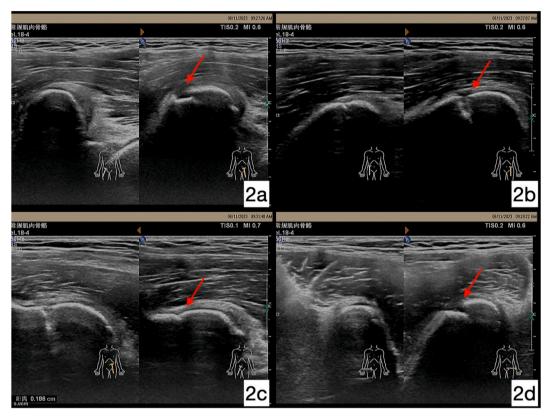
Ultrasound showing the continuity and smoothness of the cortical bone surface and the presence of interrupted linear echoes. (a-d).
